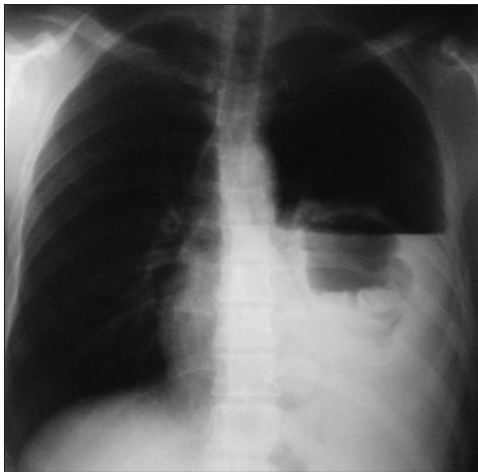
Chest X-ray: Large left-sided hydropneumothorax with significant shift of midline structures
